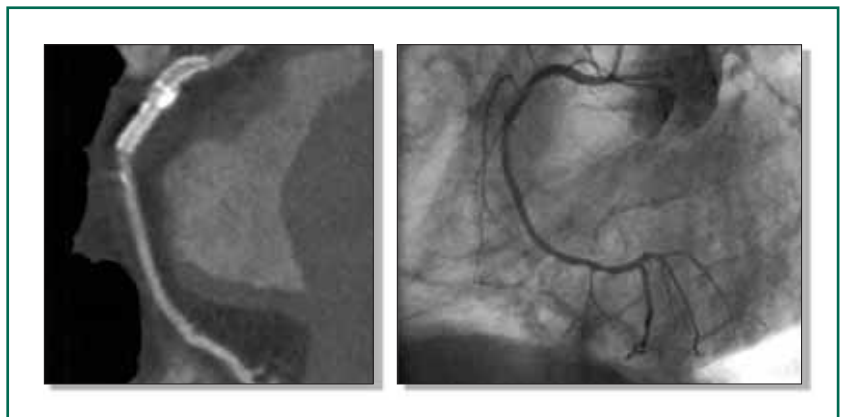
Left: Dual source computed tomography coronary angiography (CTCA) of right coronary artery (RCA) with proximal stent. Some narrowing seems to be present in the proximal portion of the stent, but this is not confirmed at conventional angiography (right). There is some artifact in the CTCA image within the mid-portion of the stent, which makes the stent not assessable by multislice computed tomography (MSCT). The result after stenting is satisfactory as assessed by conventional coronary angiography.
